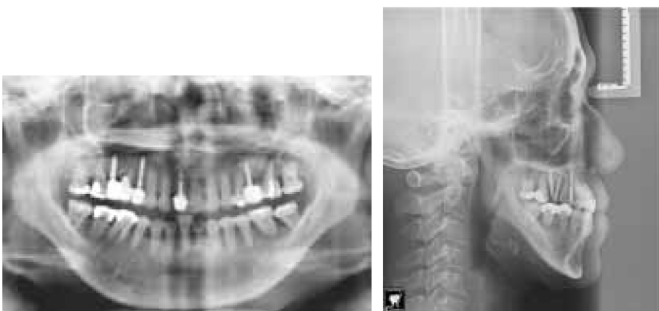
Post-treatment radiographs. A) Panoramic, B) Lateral Cephalometric. Notice there is significant improvement on the skeletal III profile due to vertical downward and backward rotation of the mandible
